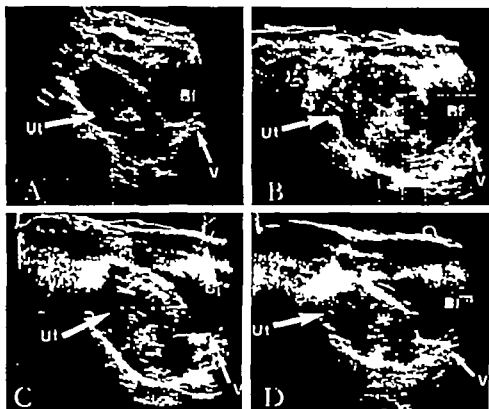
Intra-uterine volume after intra-amniotic injection of 350 ml Macrodex. Sonograms of the uterus before Macrodex infusion (A), 1 h (B), 4 h (C) and 72 h (D) after infusion. Longitudinal scan at midline. Bl = bladder, UI = uterus, V = vagina.
